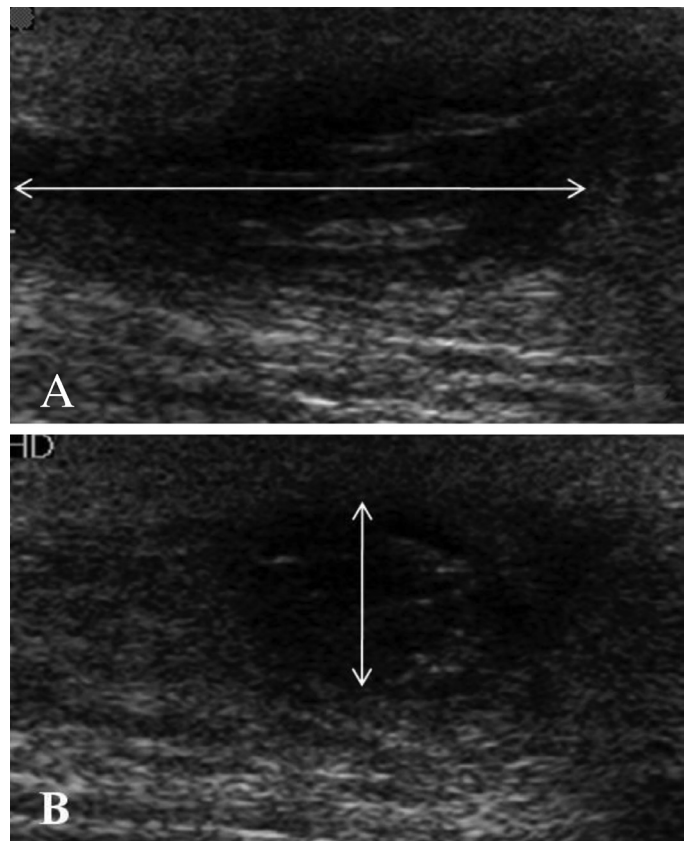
Superficial ultrasonography image of pilonidal disease. A) longitudinal ultrasonographic image of pilonidal cyst, B) vertical ultrasonographic image of pilonidal cyst
